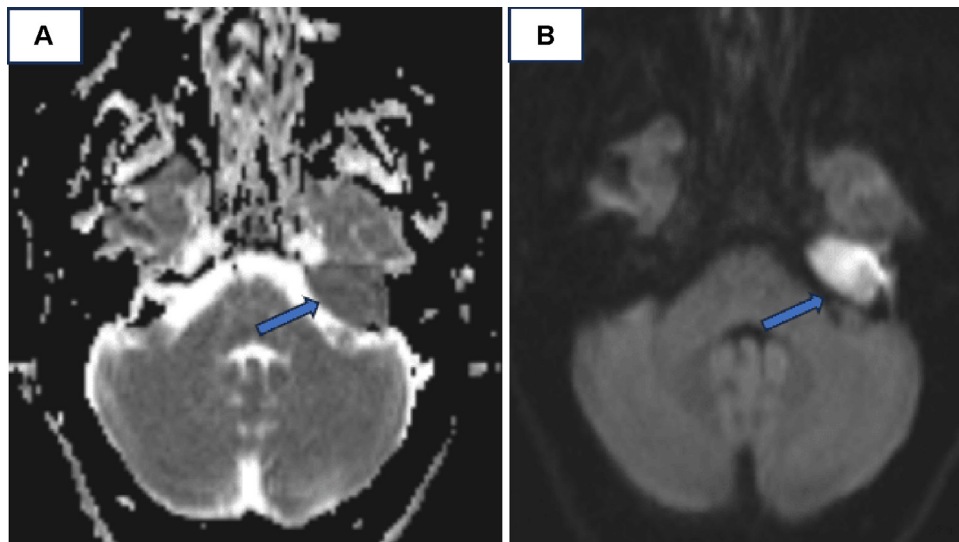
(A) DWI sequence showing a hyperintensity of the mass (Blue arrow). (B) ADC cartography showing restriction (Blue arrow).
